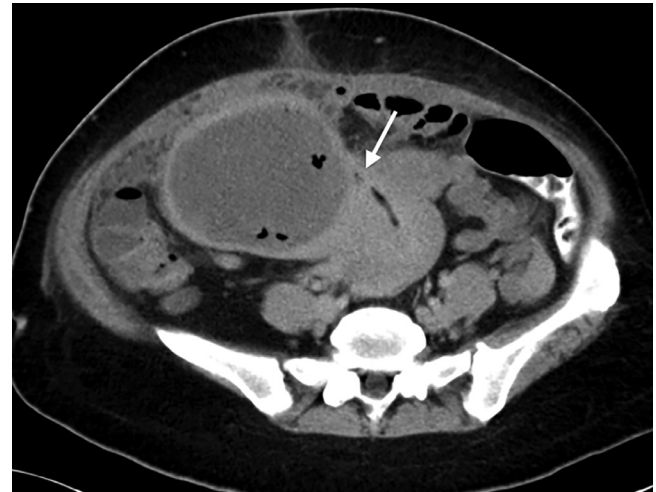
Axial reformatted contrasted CT Abdomen demonstrated a small communication track (white arrow) between the largest rim-enhancing mid-abdomen collection with the endometrial cavity indicative of a ruptured pyomyoma with fistula formation.
